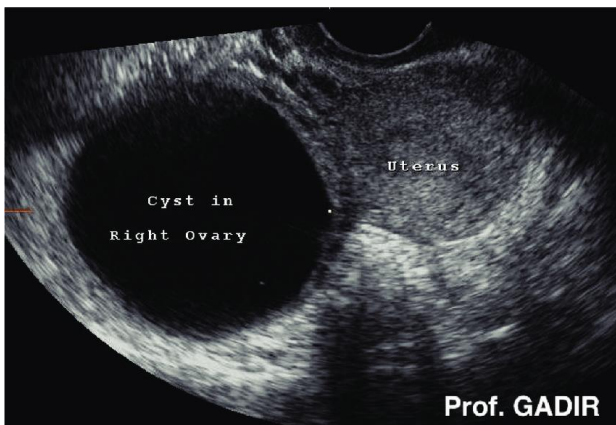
Ultrasonic pictures of different types of ovarian cysts.
